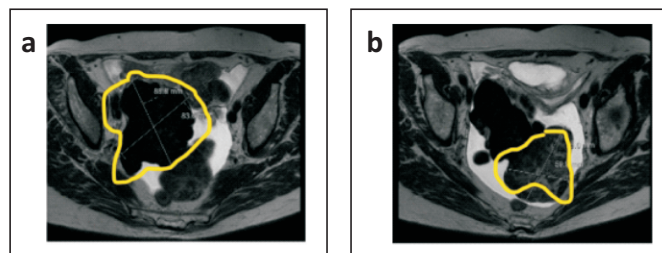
Radiological image on an MRI scan of the pelvis. Right adnexal mass measuring 8.8 x 8.4 cm. Lobulated solid mass lesion in the Pouch of Douglas measuring 7.9x5.9 cm.
